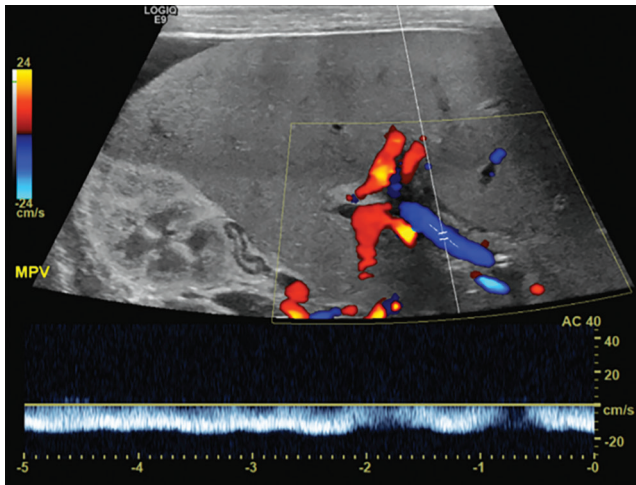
Abdominal Doppler ultrasound showing reversed portal flow
